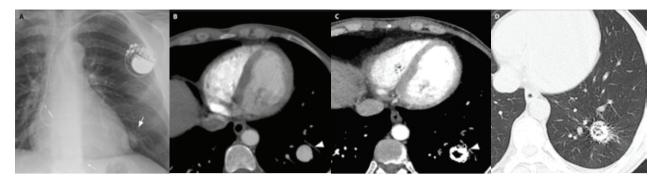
a) Preoperative Chest X ray shows a nodular radiopaque lesion at the left lower lobe (white arrow). Associated with this finding no pulmonary consolidation of a phlogistic or dysventilatory appearance were recognised. b) CE-CT on the axial plane demonstrates a saccular dilation of the pulmonary artery tributary of the posterior segment of the inferior left lobe (white arrowhead). The density measured in Hounsfield unit within the lesion was equal to that measured within the pulmonary arterial vessels, allowing us to hypothesise that there was communication between the lesion and the pulmonary circulation. The absence of pathological findings in the adjacent lung parenchyma was also confirmed. c) CE-CT on the axial plane, using SEMAR™ software at 1 month after the procedure confirmed the complete embolization of the vascular lesion: coils are leaning on the wall of the lesion without iodized contrast medium in the core (arrowhead). SEMAR™ significantly reduced beam hardening artefacts so that revascularization of the lesion could be excluded with certainty. d) CE-CT on the axial plane, using SEMAR™ software at 1 month after the procedure, (lung window), neither demonstrates no signs of pulmonary infarction in the lung parenchyma surrounding the coils or in the more peripheral subpleural areas.
